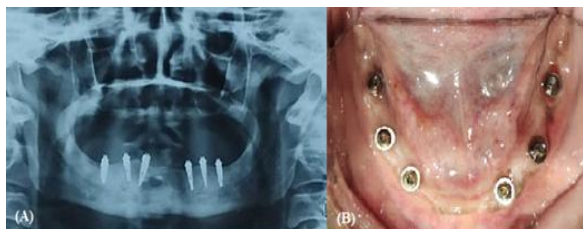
(A) Panoramic radiograph after 4 months showing successful osseointegration of the six mandibular implants (B) Healed peri-implant soft tissues at 4 months
